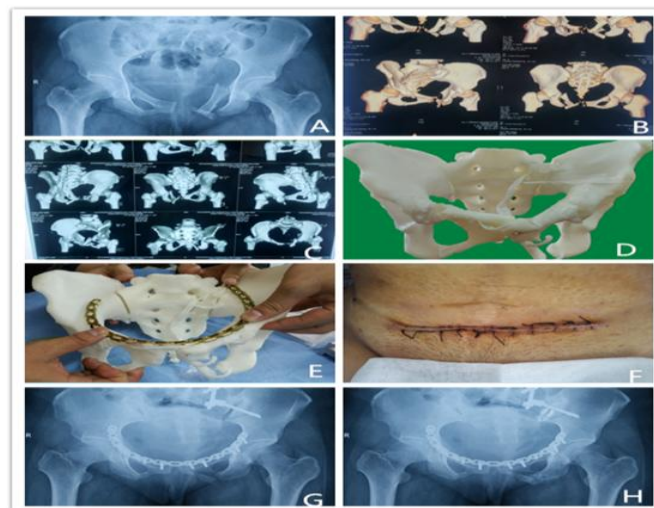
Application of 3D printed orthopedic models in trauma orthopedics. Patient information: Female, 23 years old, multiple injuries from car accident, Tile type B2 fracture of pelvis. A: Preoperative X-ray films; B: Preoperative THREE-DIMENSIONAL reconstruction; C: preoperative CT film; D: preoperative 3D printing model; E: Prebend the steel plate according to 3D model before surgery; F: Postoperative X-ray film.
